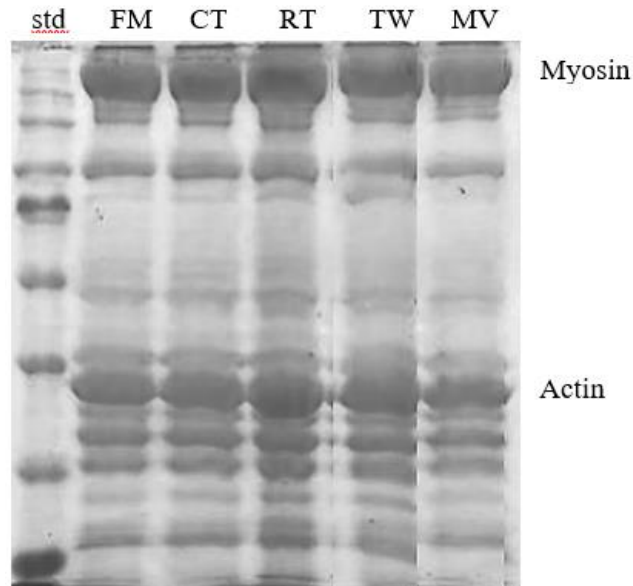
Representative SDS-PAGE showing the myofibrillar protein bands of *longissimus lumborum* muscle in beef subjected to chill temperature (CT), room temperature (RT), tap water (TW) and microwave (MW) thawing in comparison to fresh meat (FM).
